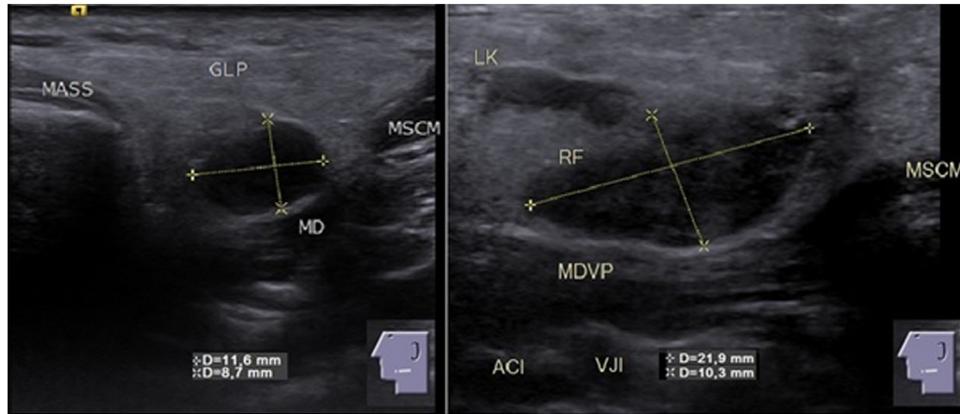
Left: Sonographic picture of a lesion in the left parotid gland eight months after extracapsular dissection and verification of a cystadenolymphoma on the same side. Right: The same lesion 55 months later, with a considerable increase in growth (GLP: parotid gland, MASS: masseter muscle, MD: digastric muscle, MSCM: sternocleidomastoid muscle, LK: lymph node, MDVP: posterior belly of the digastric muscle, ACI: internal carotid artery, VJI: internal jugular artery).
